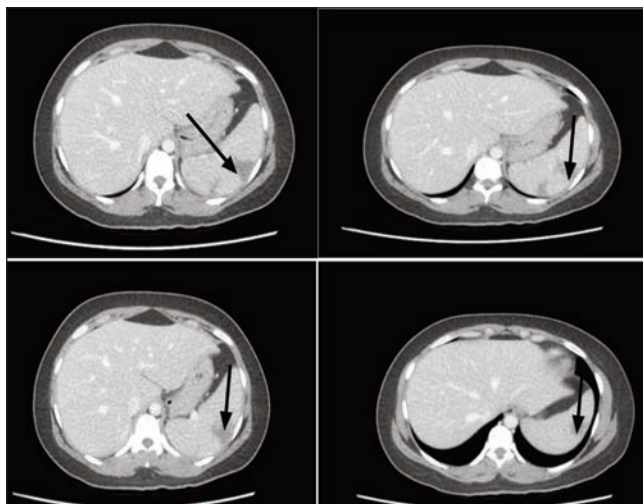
Splenic infarcts in the CT scan abdomen (axial view) with contrast (arrows are pointing to the infarcts).
